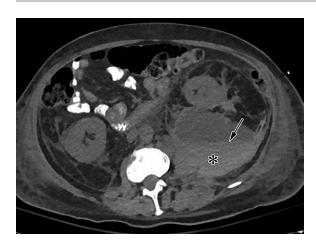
Retroperitoneal hematoma in a 45-year-old man with a history of trauma. Axial nonenhanced CT image shows a left retroperitoneal lesion with high-attenuation blood (*) and a fluid-fluid level (arrow), typical for retroperitoneal hematoma.
